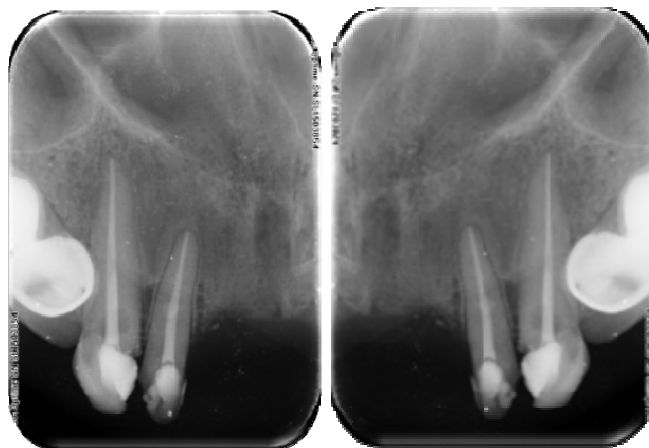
Radiographs after obscuration
